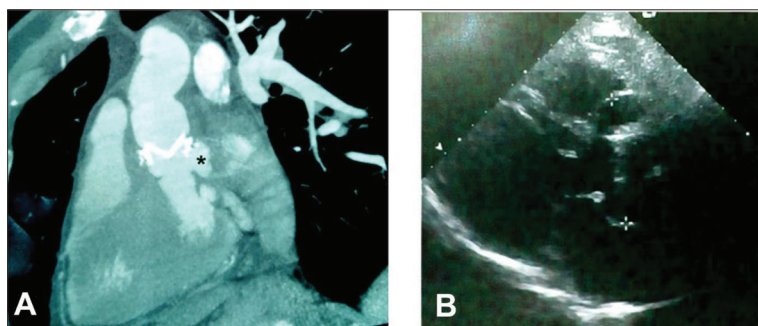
A – postoperative chest multidetector computed tomography: an emptied subvalvular abscess (black asterisk); B – postoperative echocardiography: periprosthetic pseudoaneurysm (white asterisks)
